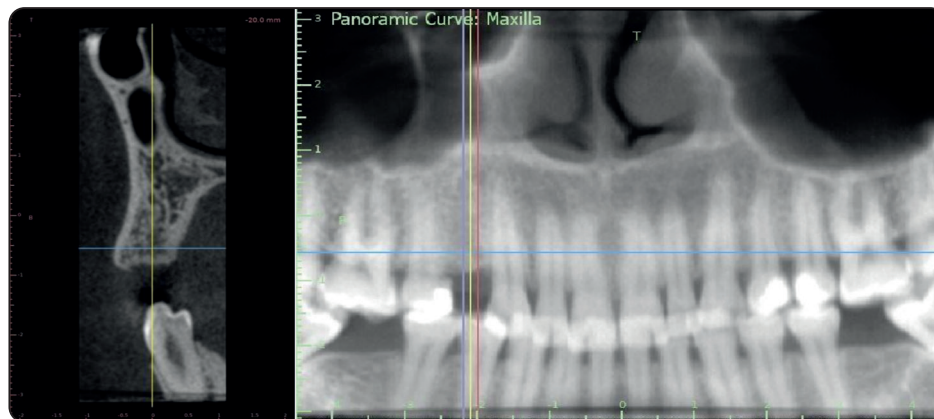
Preoperative CBCT image showing the missing tooth
